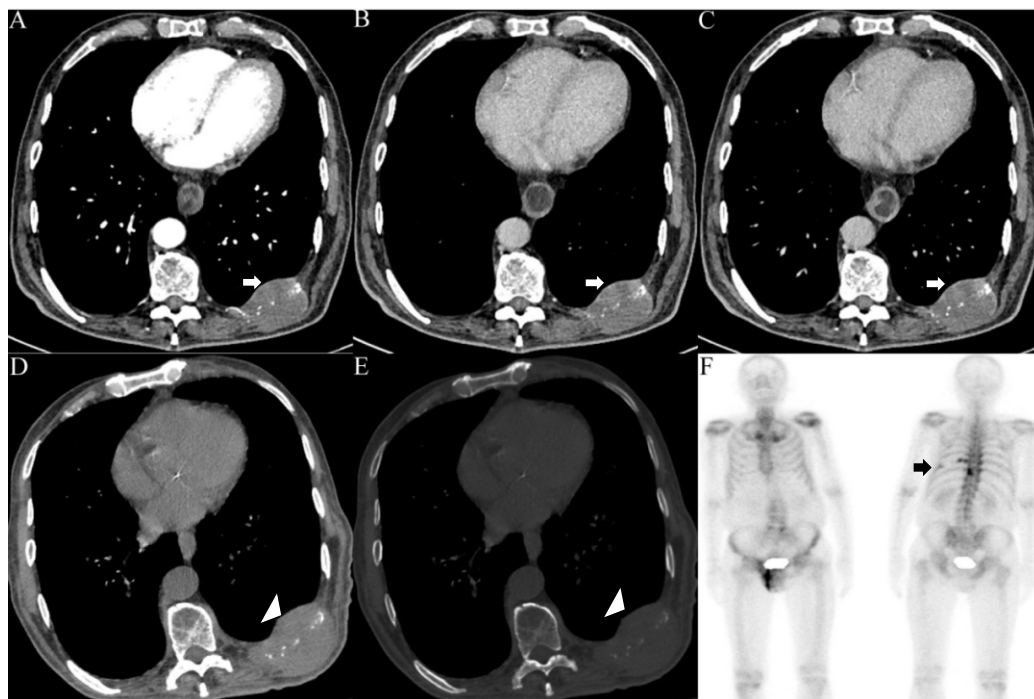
A 77-year-old male patient presented with two months of persistent upper abdominal pain and was subjected to an enhanced chest CT scan. The scan revealed a soft tissue mass with osteolytic destruction at the left 9th rib, measuring 4.2x5.6cm. Axial CT images in the mediastinal window (white arrows) demonstrated the lesion with arterial phase Hounsfield Units (HU) of 38 (A), venous phase of 37 HU (B), and delayed phase of 39 HU (C). Follow-up non-contrast CT two months later, showed an increase in size of the osteolytic lesion to 5.3x7.6cm on axial images (white arrowheads) through the mediastinal (D) and bone windows (E). Technetium-99m-MDP scintigraphy (F) depicted a significant decrease in tracer uptake in the left 9th rib soft tissue mass area with increased surrounding bone uptake (black arrow).
